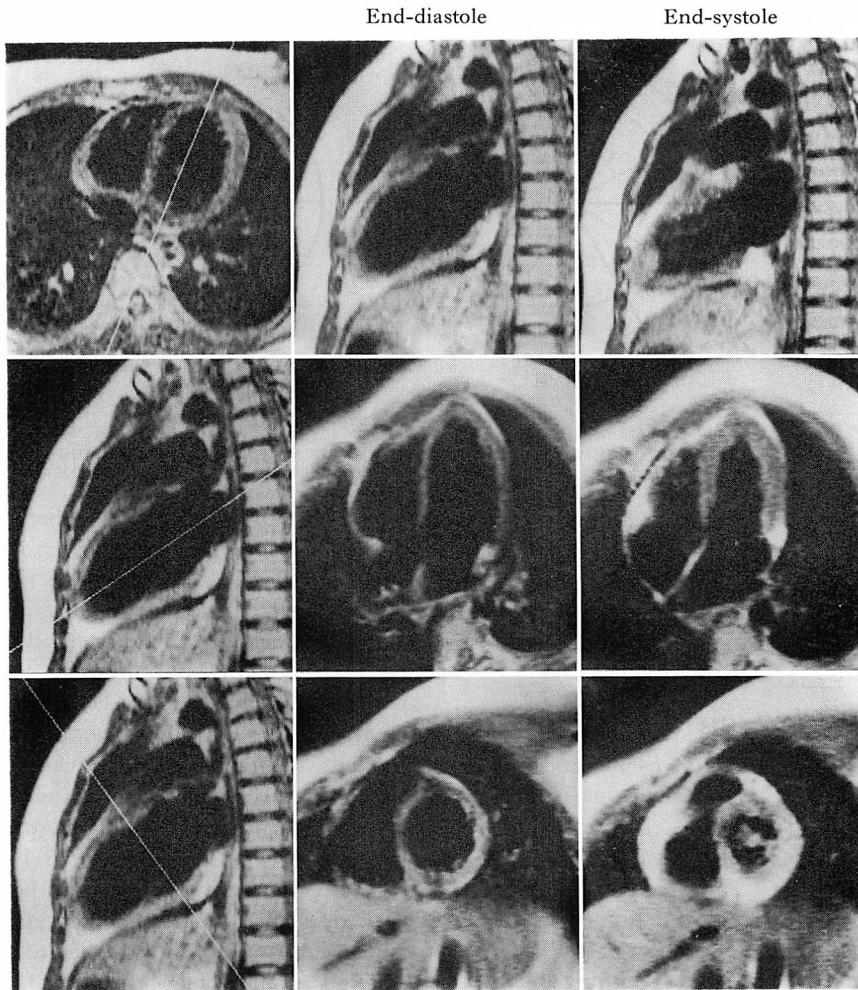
Magnetic resonance imaging with optimal axis in a normal subject.
